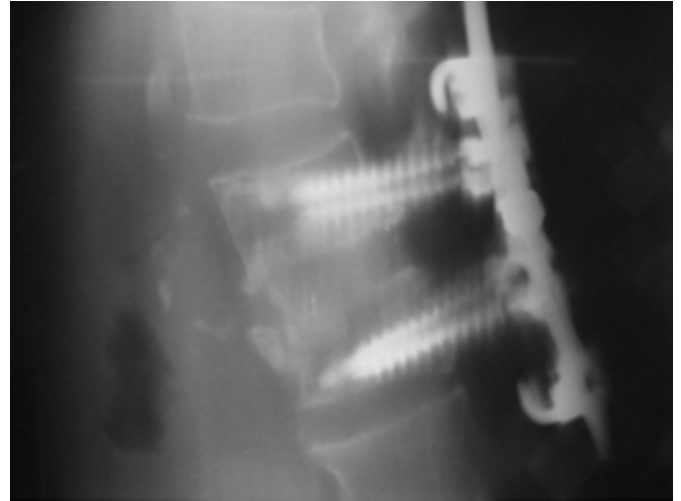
a. Post-operative MRI on sagittal view showed the bone grafts and interbody cage(Brantigan's carbone I/F cage) between L3 and L4. b. The dural sac was decompressed and the nerve roots in the dura are located in the center of the spinal canal.
